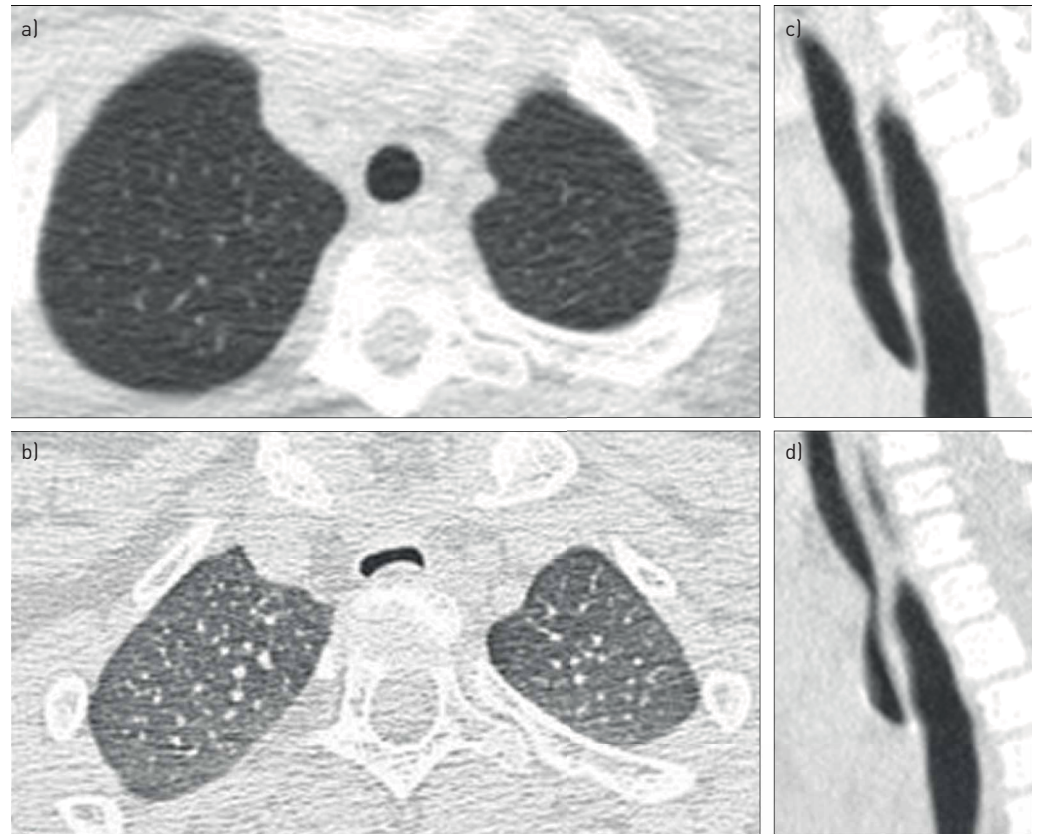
Paired end-inspiratory and end-expiratory multidetector computed tomography scans of the chest: axial scan at a) end-inspiration and b) end-expiration phase and sagittal multiplanar reconstruction at c) end-inspiration and d) end-expiration phase showing significant expiratory reduction in the cross-sectional luminal area of the trachea. The appearance is consistent with tracheomalacia.
